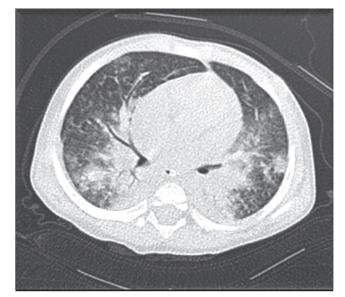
Appearance of bilateral paramediastinal infection on computed tomography of the thorax suggesting invasive fungal infection in the lung in case 4
